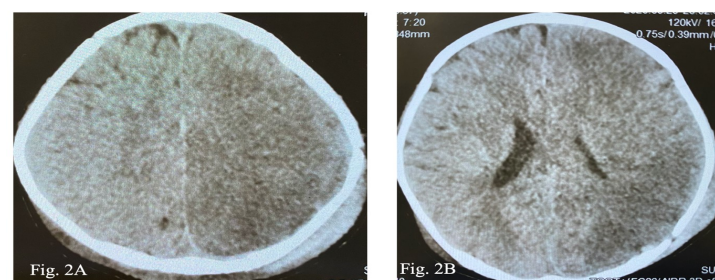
A and B) Computerized tomography (CT), axial section showing an infarction in the Middle Cerebral Artery territory on the third day.
